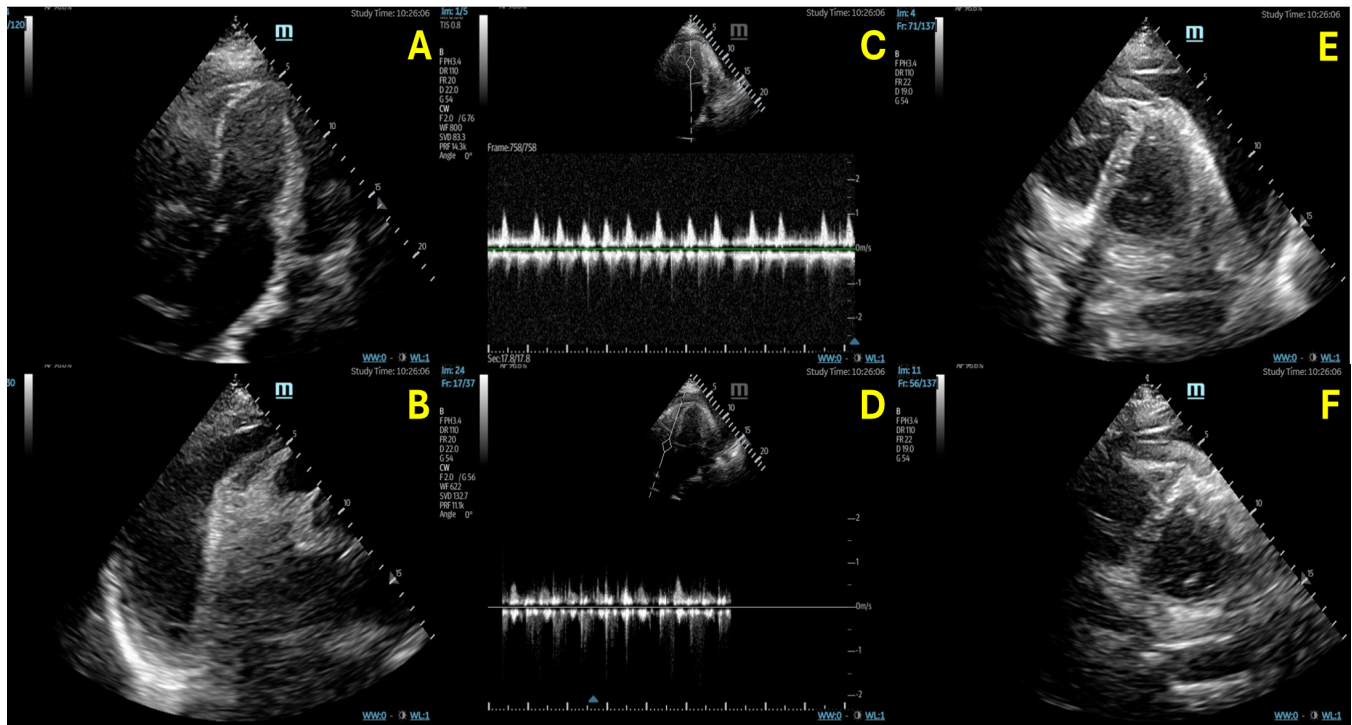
POCUS findings. Apical 4 chamber showing large circumferential pericardial effusion with evidence of RV dilation (A) and absence of right atrial or right ventricular collapse. Modified parasternal long-axis showing large pericardial effusion (B). Transvalvular Doppler inflow patterns demonstrating absence of exaggerated respiratory variation across the mitral (C) and tricuspid (D) valves. Parasternal short axis showing flattening of septum during both diastole (E) and systole (F).
